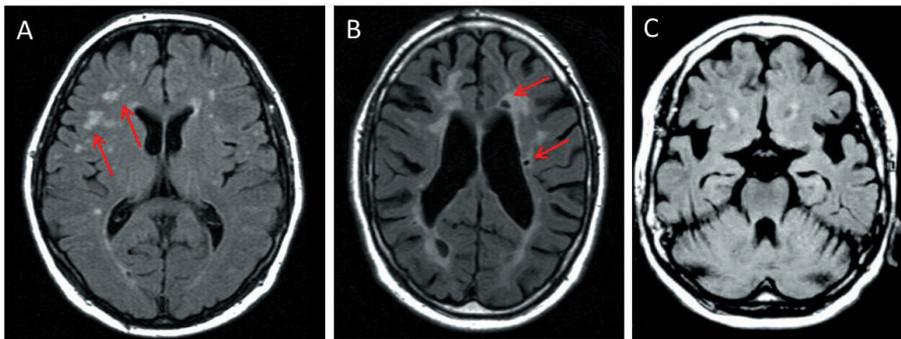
MRI markers of small vessel disease and Vascular Cognitive Impairment: white matter hyperintensities (A), lacunar infarcts (B) and global brain atrophy (C)
